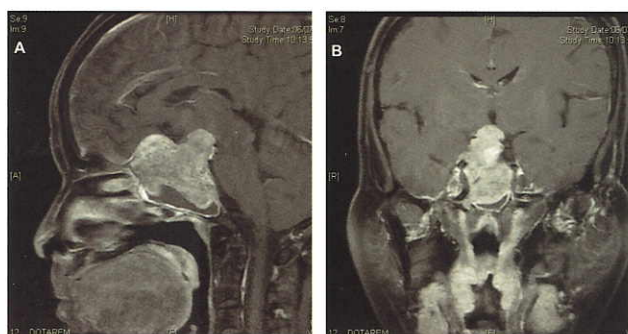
Magnetic resonance imaging (MRI) of a large pituitary tumour with suprasellar extension. An endonasal transsellar and transplanum approach is used to remove the tumor. Figures A and B are the pre-operative scans and Figures C and D are the post-operative scans.
